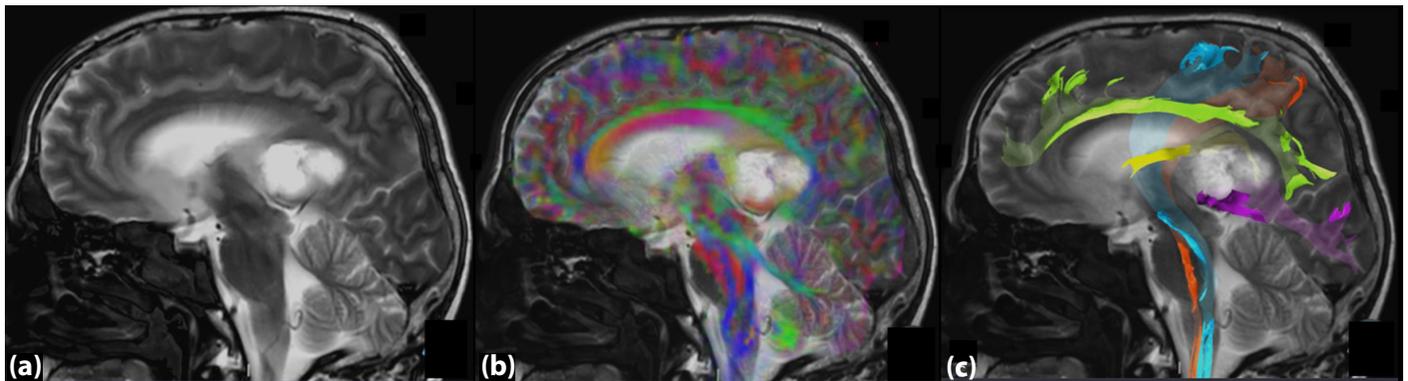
A sagittal T2-weighted image (a), color-coded fractional anisotropy (FA) map (b), and tractography reconstruction (c) demonstrate lesion-induced displacement of the corticospinal tract (CST, red), medial lemniscus (ML, blue), fornix (FX, yellow), and cingulum (CI, green). The forceps major (FM, pink) exhibits both displacement and disruption secondary to the lesion.
